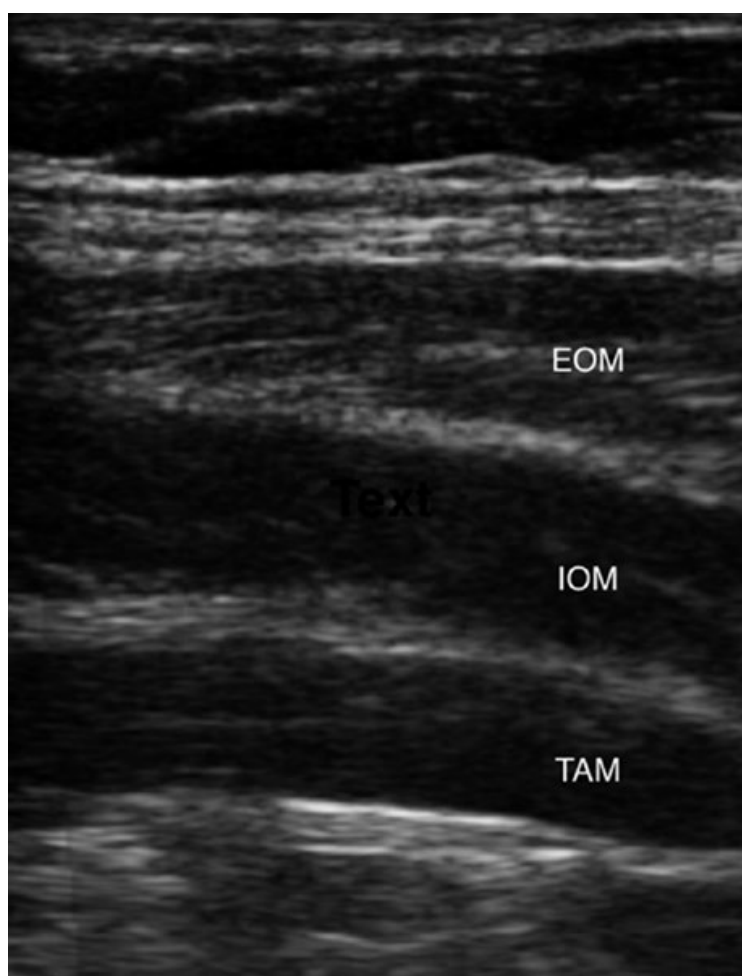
Transverse ultrasound anatomy of the abdominal wall
